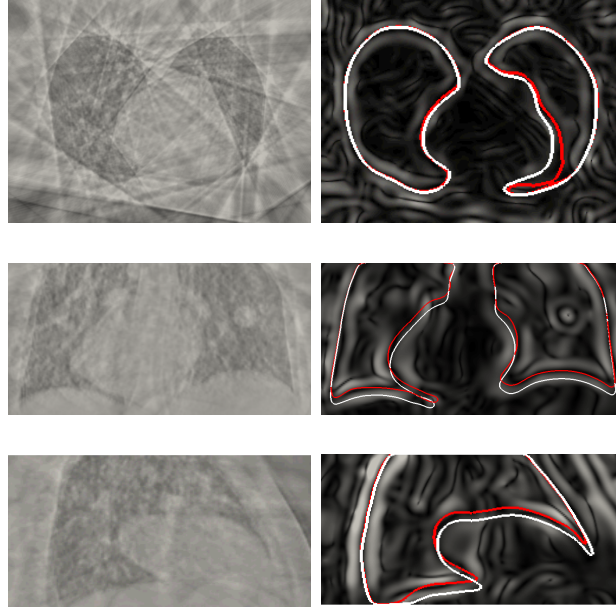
An example of CBCT deformable model segmentation. Left: The axial, coronal and sagittal slices of a NCAT CBCT (at EE phase) image. Right: The axial, coronal and sagittal slices of the second-order-gradient magnitude image are shown with the final segmentation contours (in red) and the initial mean shape model (in white).
